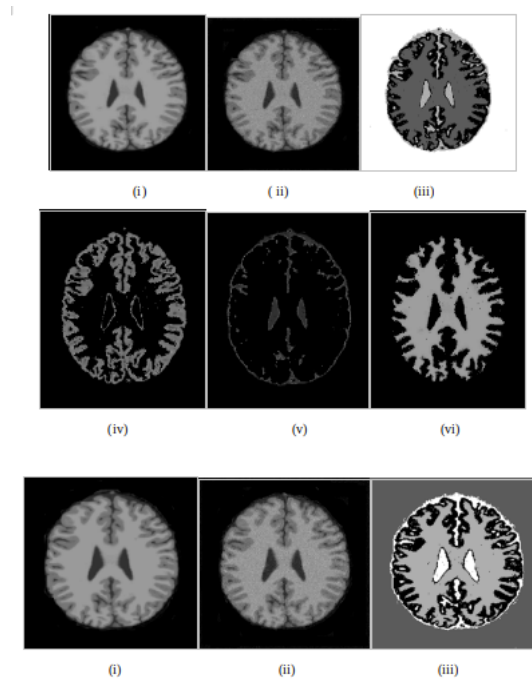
(i) MRI T1-100, (ii) MRI with 3% noise, (iii) MRI segmented using ACO-FCM, (iv) MRI with Gray, (v) CSF, (vi) MRI with White
